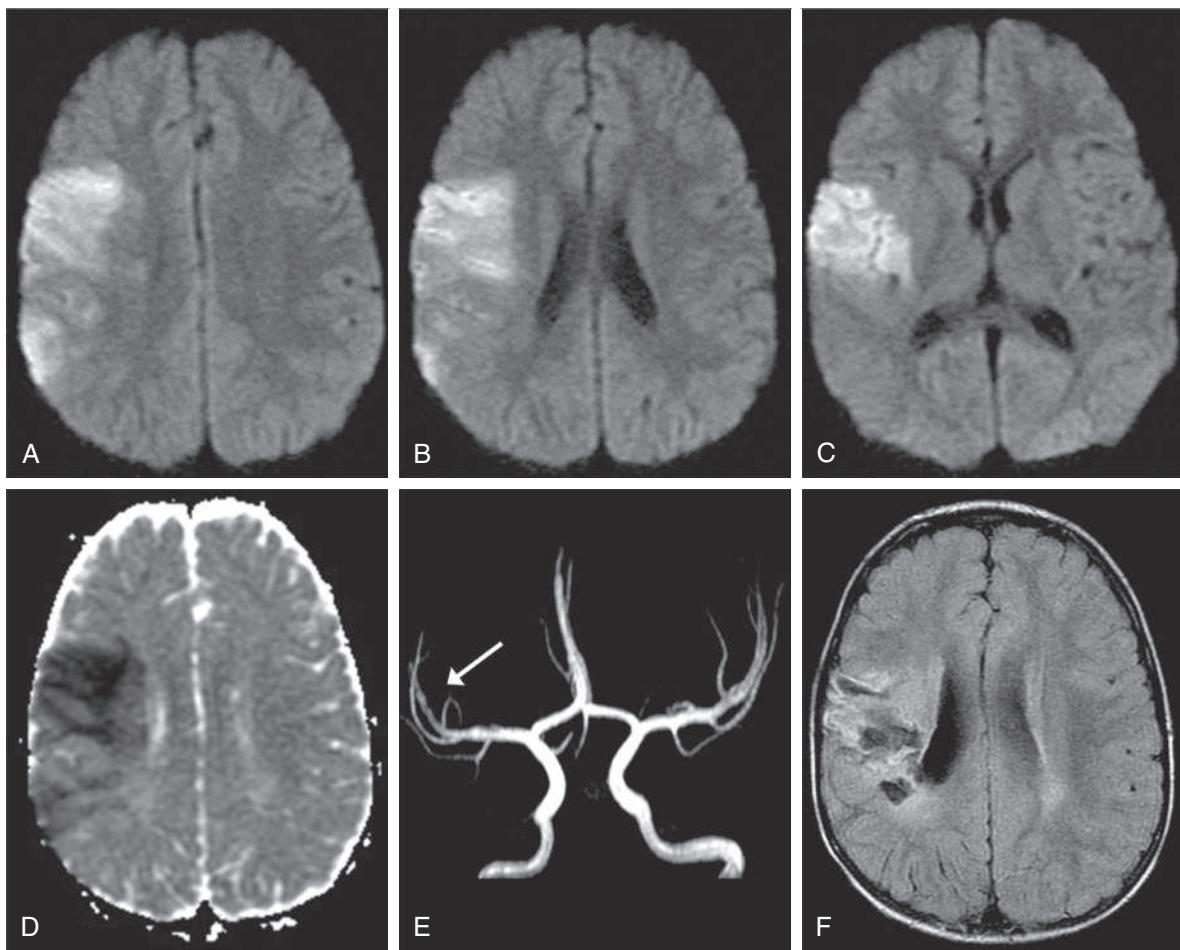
Arterial ischemic stroke. A healthy 3-yr-old male had sudden onset of left-sided weakness. Examination also demonstrated left-sided hemisensory loss and neglect. A-C, Diffusion-weighted MRI shows focal increased signal in the right temporal-parietal region in the territory of the middle cerebral artery (MCA). D, Apparent diffusion coefficient map confirms restricted diffusion consistent with infarction (ischemic stroke). E, MR angiogram shows decreased flow in the corresponding branch of the MCA. F, Follow-up MRI at 3 mo shows atrophy and gliosis in the same region.
